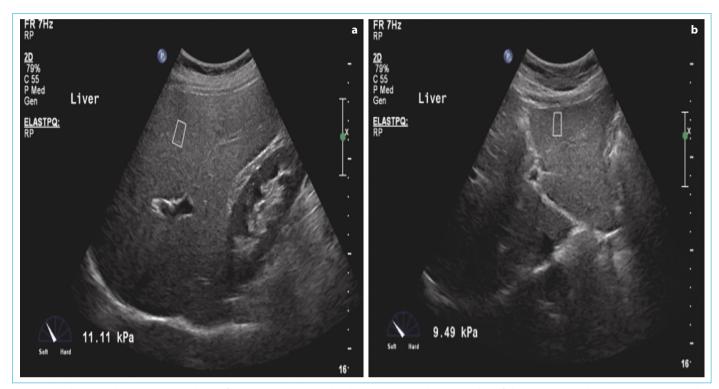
Ultrasound images show the stiffness values obtained in kPa in (a) right lobe and (b) left lobe by SWE (Shear-Wave Elastography) method.
